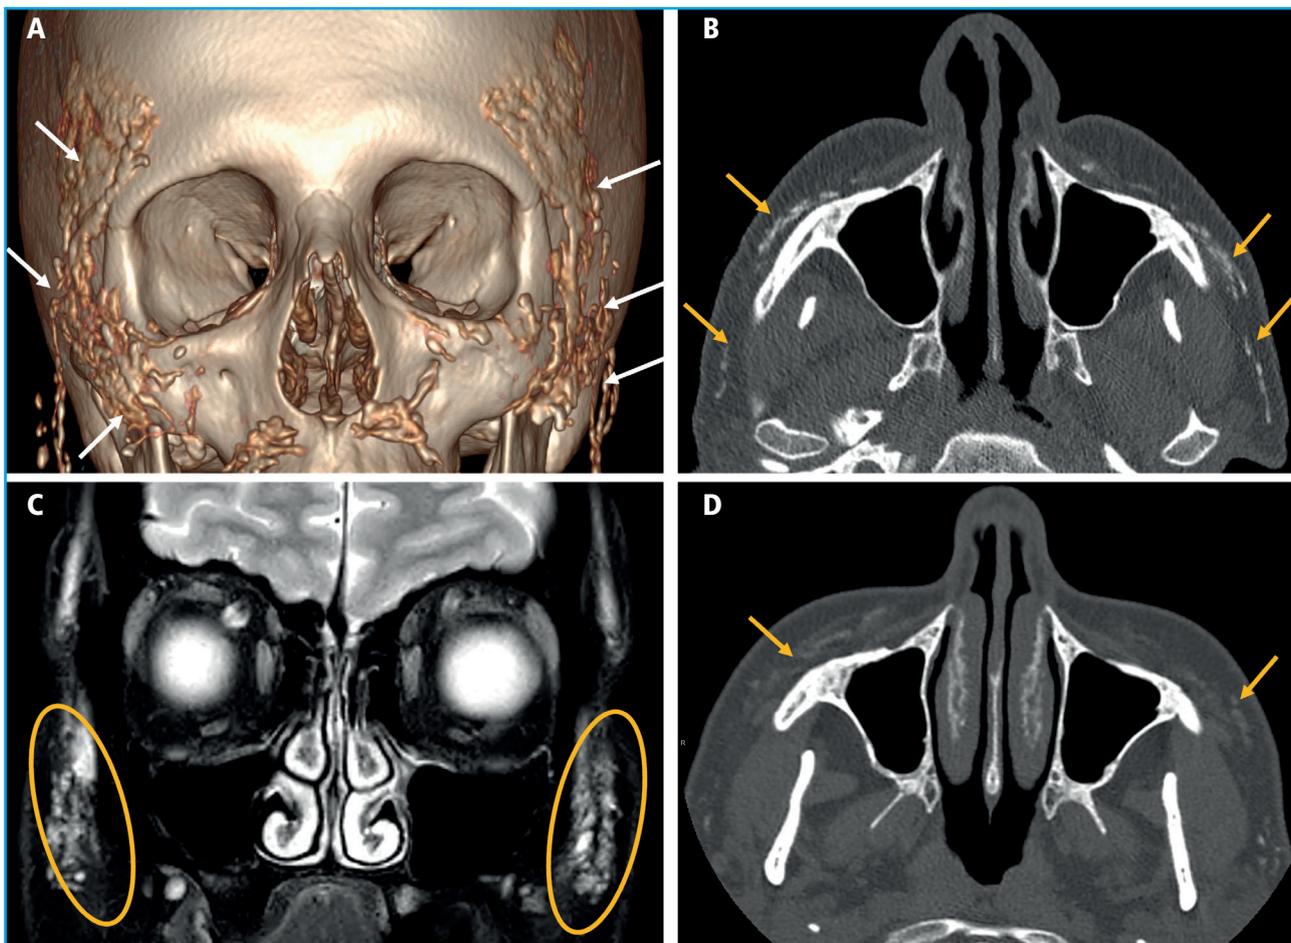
A. 3D reconstruction of a facial CT scan. B. Axial image of a facial CT scan without contrast. C. Coronal image of a T2-weighted fat-saturated magnetic resonance imaging (MRI) sequence. D. Axial image of a facial CT scan without contrast 3 years after the Radiesse® injection. Multiple hyperdense foci are evident in the CT scans (A and B), diffusely distributed across the subcutaneous cellular tissue of, predominantly, the zygomatic, infraorbital, and buccal regions, corresponding to calcium hydroxyapatite deposits. The MRI (C) shows these deposits overtly hyperintense on the T2-weighted imaging. Significant product resorption can be seen after 3 years (D), with thin residual deposits.
